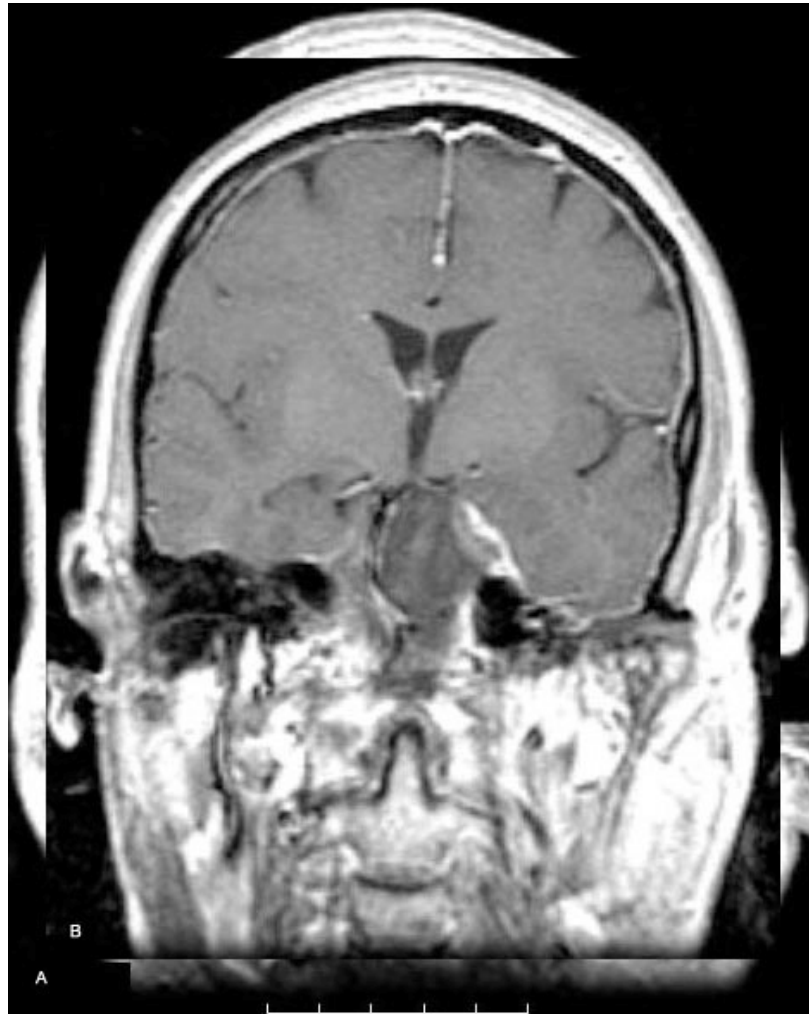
Coronal postcontrast MRI showing a large petroclival meningioma (A). A near complete resection was performed using a combined supratentorial and infratentorial approach via the orbitozygomatic and retrosigmoid craniotomies in a staged manner. Residual tumor (B) was treated with stereotactic radiosurgery.
